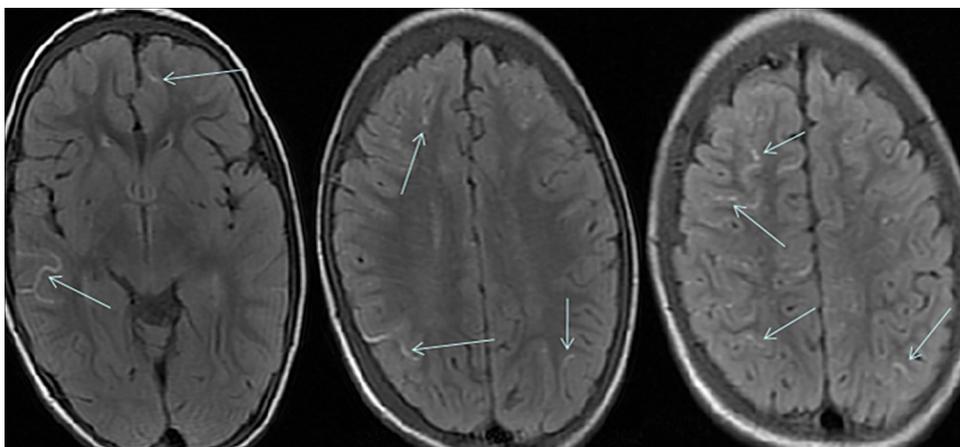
Axial consecutive FLAIR images show bright sulci (arrows) consistent with slow flowing engorged pial vessels (ivy sign).
